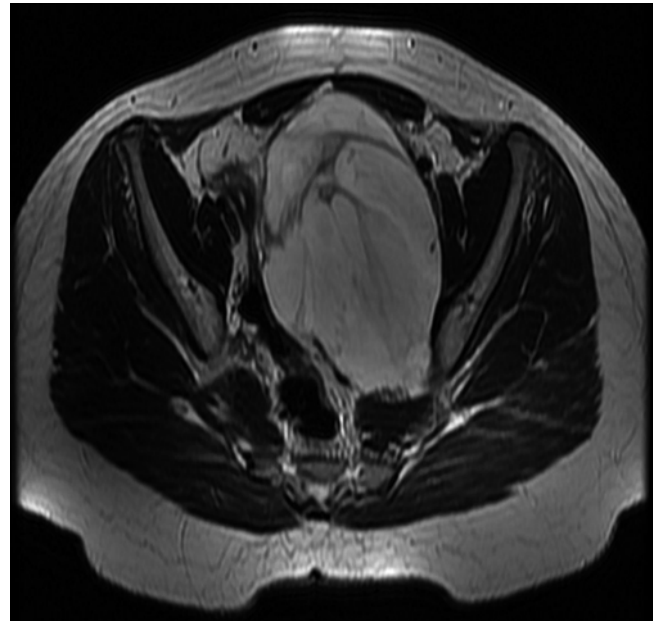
A 17 year-old girl presented with pain in her left thigh. MRI abdomen showed a large pelvic mass. She underwent incomplete resection of a myxoid liposarcoma with pleomorphic elements followed by second look operation and resection of metastatic disease with hyperthermic intraperitoneal chemotherapy (HIPEC)
